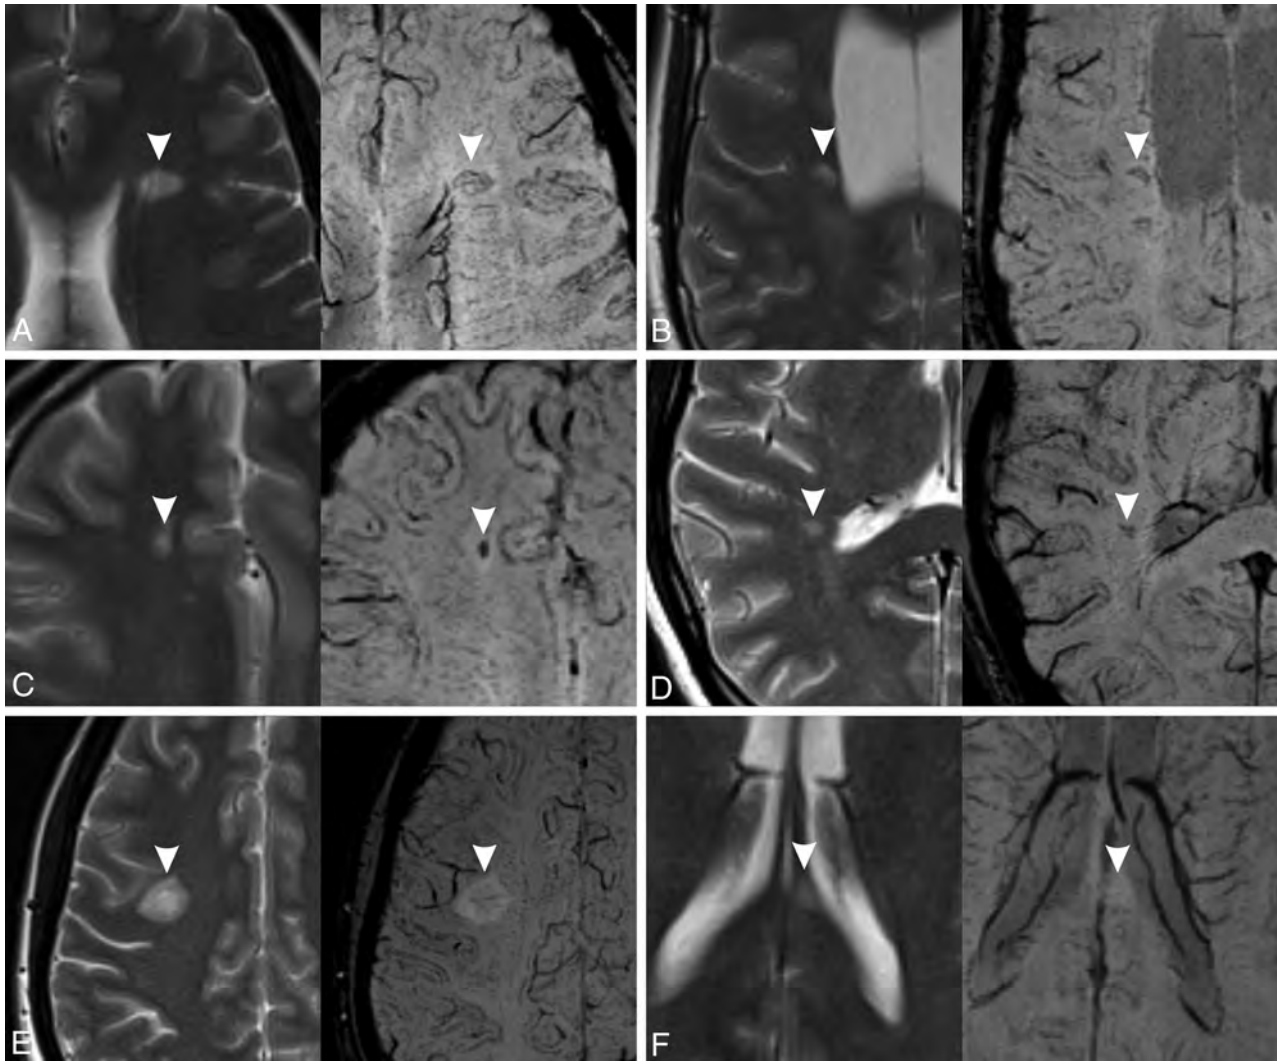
Signal categories on SWI (right) with the corresponding T2-weighted images (left). The lesions are marked with *arrowheads*. A, Hypointense ring (complete). B, Hypointense ring (partial). C, Marked hypointensity (*dot-shaped*). D, Marked hypointensity (*irregularly shaped*). E, Mild hypointensity. F, Iso-/hyperintensity. In A, B, and E, the central vein sign is also visible.
